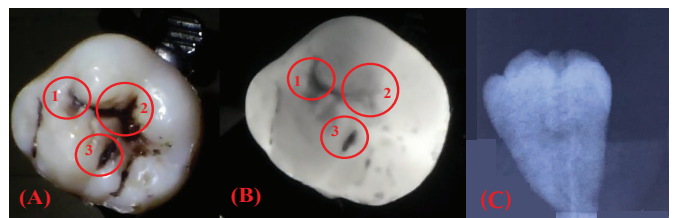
Sample 5 under visible light (A), NIR light (B), and X-ray (C).
